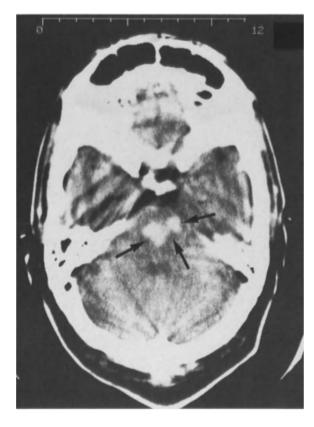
CT scan showing a pontine hemorrhage (*arrows*) due to autonomic dysreflexia. This 32-year-old patient died as a result of the hemorrhage
